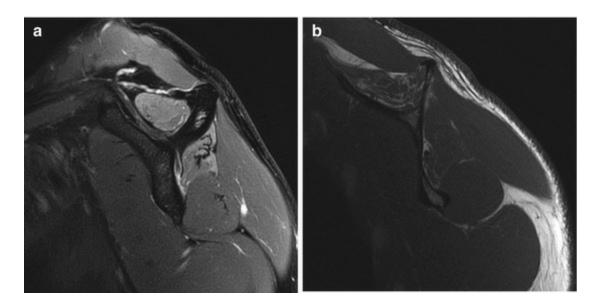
A 43-year-old man with Parsonage-Turner syndrome due to an isolated right suprascapular nerve palsy mimicking a nerve entrapment syndrome. (a) Sagittal fat-suppressed T2-weighted MRI shows a muscle edema of the supraspinatus and infraspinatus muscles. (b) Sagittal T1-weighted MRI shows atrophy and fatty degeneration of the supraspinatus and infraspinatus muscles. Note the fatty degeneration is more severe for the supraspinatus muscle
